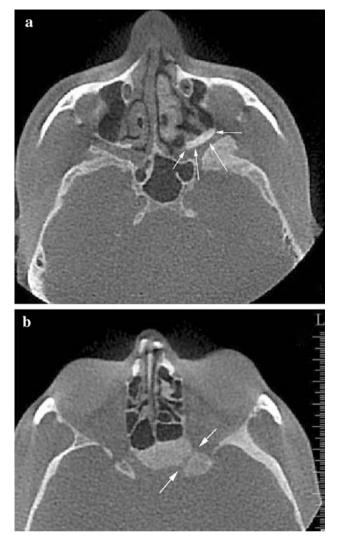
Axial CBCT scan shows a affected bone on the left posterior maxillary sinus wall (*arrows*) and b narrowed left optic canal (*arrows*)
